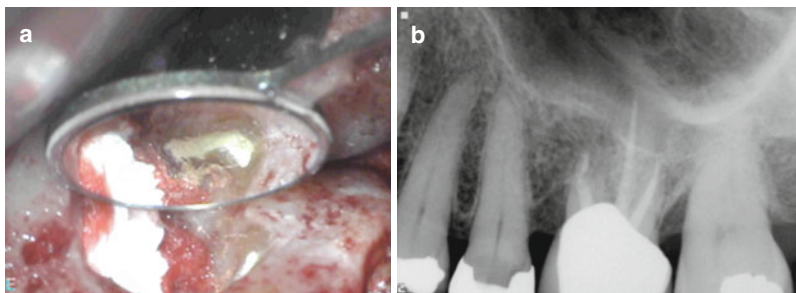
Continuation of case presented in Fig. 6.4: root-end filling with MTA (a). Postoperative radiograph (b). 8-year recall CBCT demonstrating the coronal (c), sagittal (e), axial (d), and 3D rendering (f). Complete bone regeneration of the buccal plate as well as the floor of the sinus can be visualized
